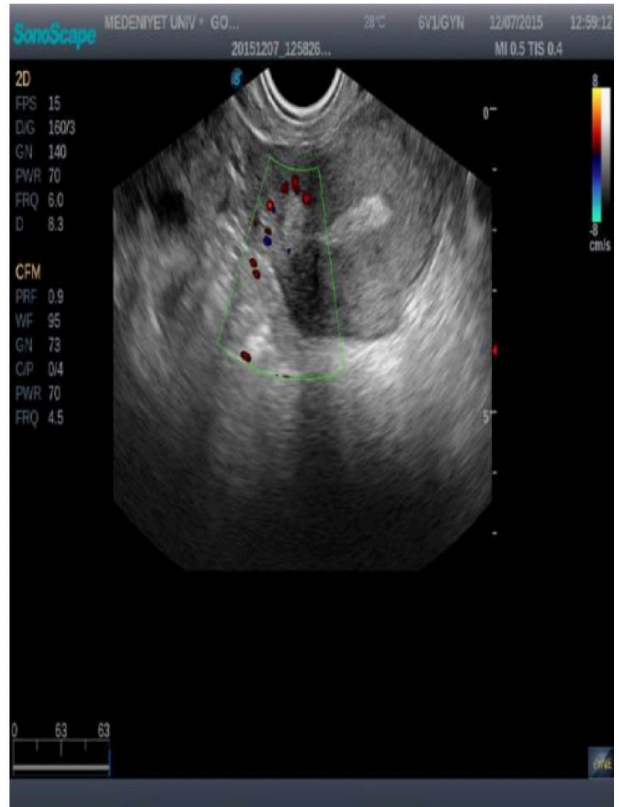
Ultrasound image of the uterus after one month of laparoscopic occlusion of the internal iliac arteries
